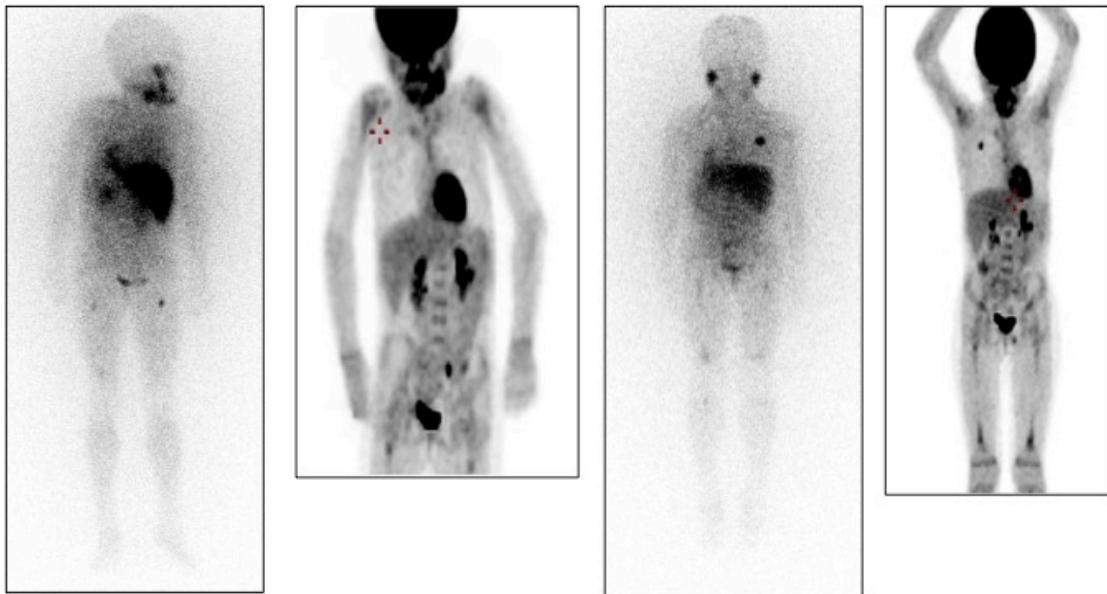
^{123}I -mIBG planar scintigraphy and ^{18}F -FDG PET MIP images for Patient 15 pre and post ^{131}I -mIBG therapy. This patient had progressive disease on both imaging modalities with SIOPEN score for ^{123}I -mIBG increasing from 9 to 14 and increasing on ^{18}F -FDG PET from 19 to 26.
